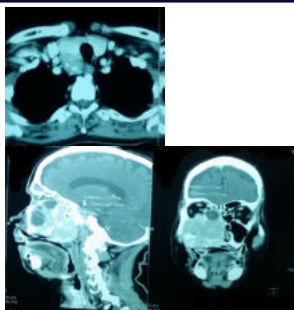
Axial images of CT Neck showing the parathyroid tumor
